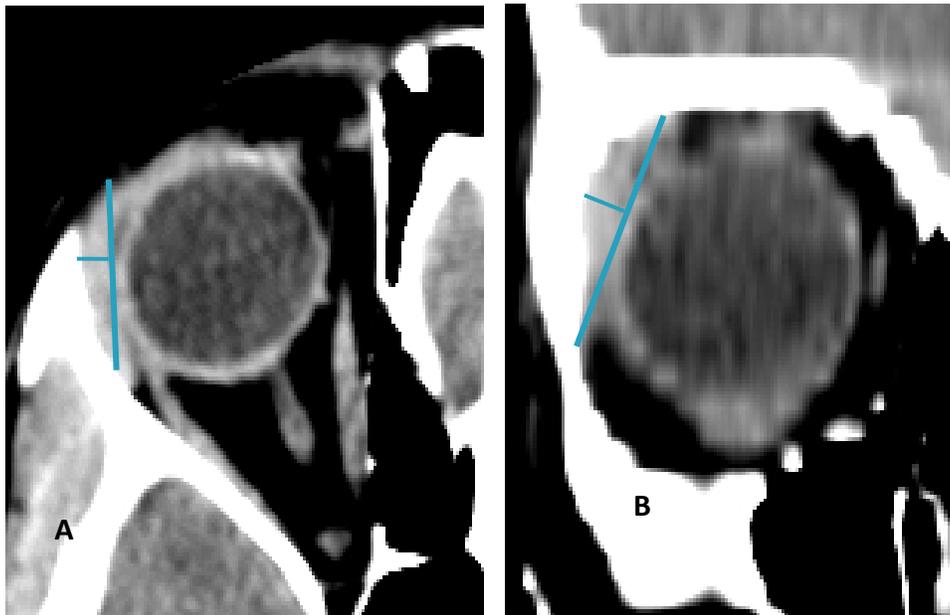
Axial and coronal CT showing the length (blue solid thick line) and width (blue thin line). A, showing the axial length (blue solid thick line) measured from the anterior to posterior tips and axial width (blue thin line) measured from the widest point perpendicular to the length. B, showing the coronal length (blue solid thick line) measured from the superior to inferior tips and coronal width (blue thin line) measured from the widest point perpendicular to the length.
